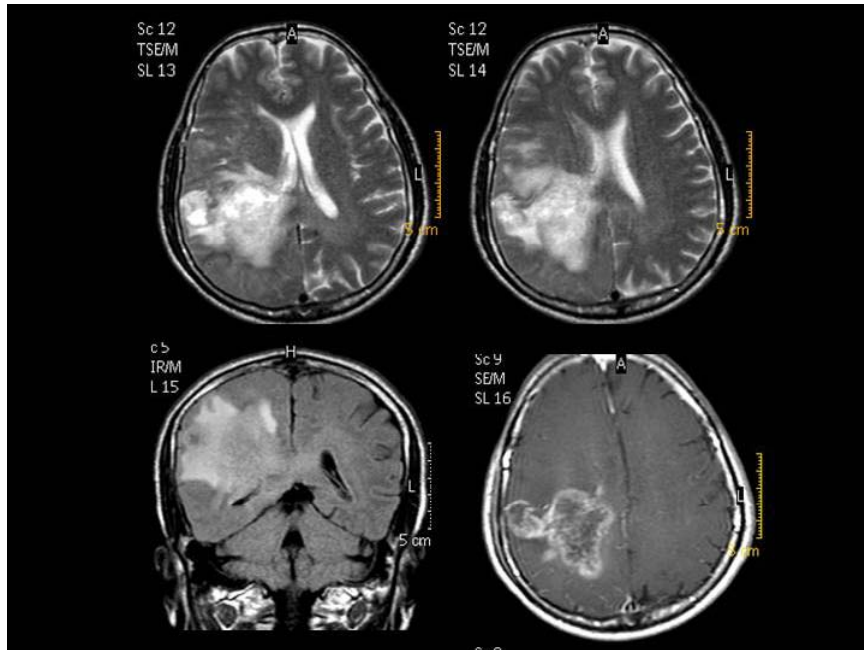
A.MRI shows a large, irregular, infiltrative, peripheral enhancing necrotic lesion with edema and mass effect in the right temporo parietal lobe representing high grade neoplasm
